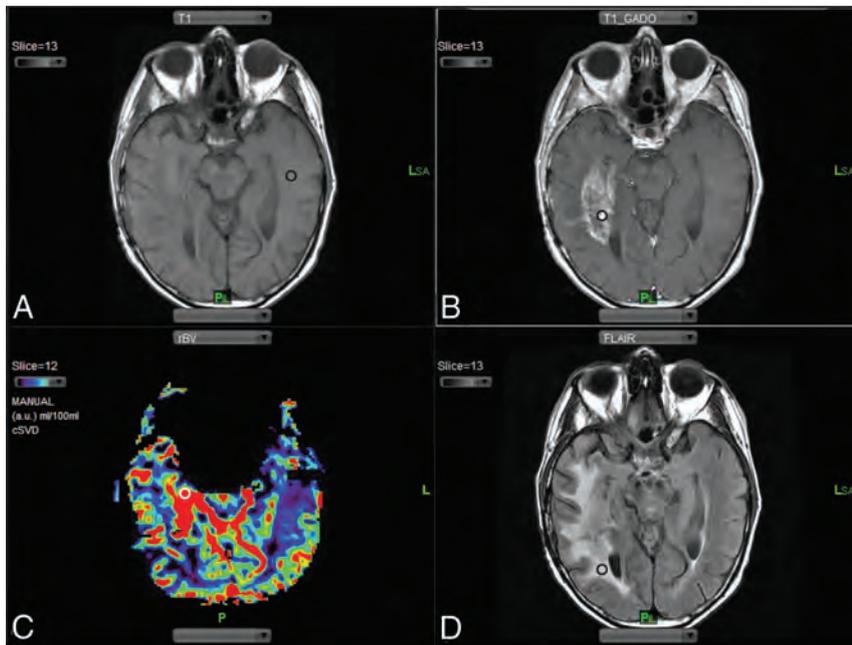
ROI selection. A, Precontrast T1-weighted images are used to select the ROI in the normal-appearing white matter on the side contralateral to the lesion (black circle). B, Postcontrast T1-weighted images are compared with the precontrast T1-weighted images to select the ROI representing the area of max contrast enhancement (black circle). C, Region of max rCBV is selected by using rCBV maps (white circle). D, T2-FLAIR images are used to select areas representing the nonenhancing T2 hyperintense signal abnormality surrounding the tumor (black circle).
